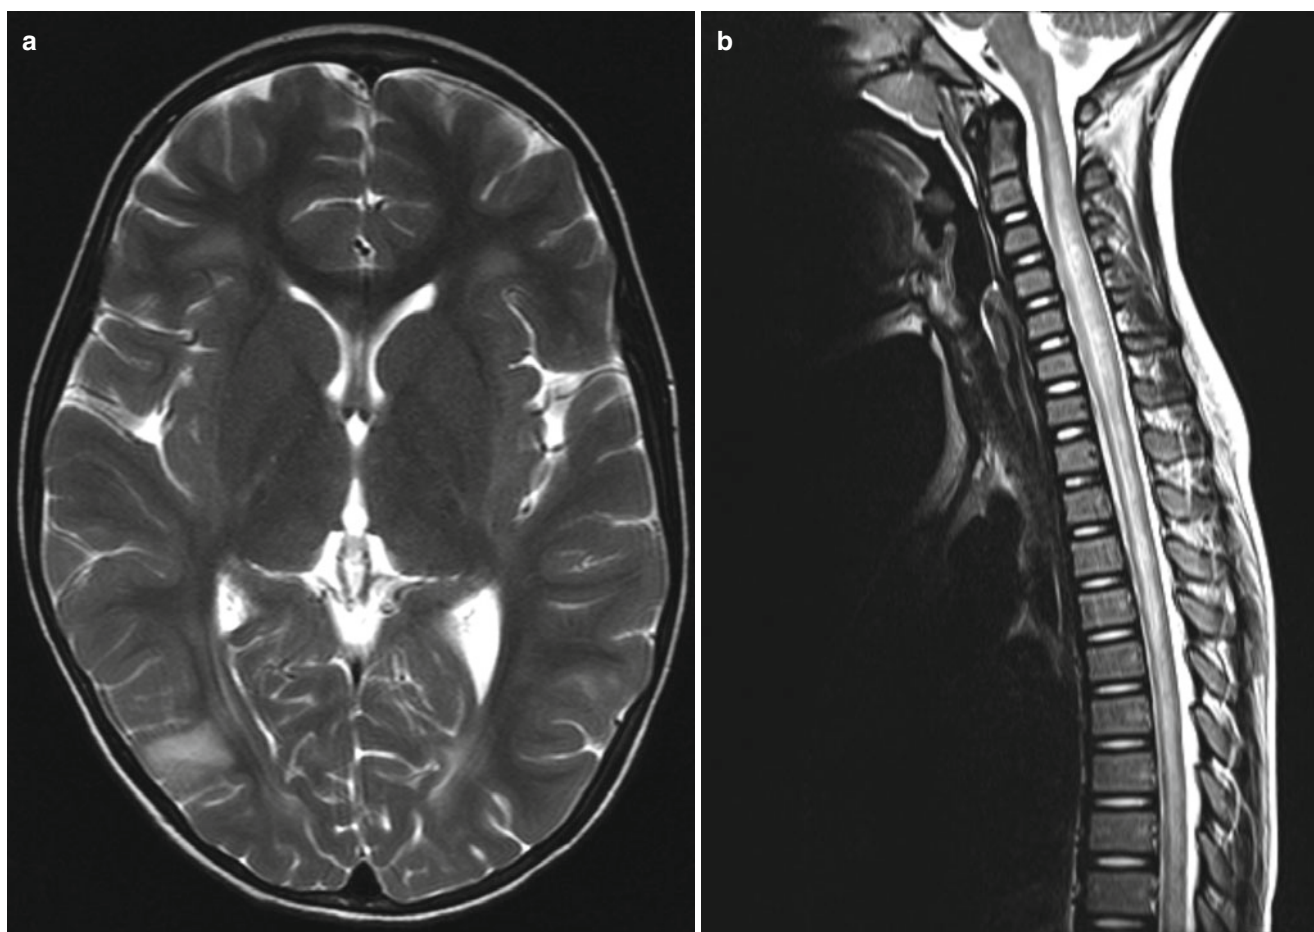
ADEM in a 6-year-old girl with paraplegia and urinary difficulties. (a) T2-weighted image shows multiple patch subcortical and deep white matter lesions. (b) T2-weighted image of the spine shows
